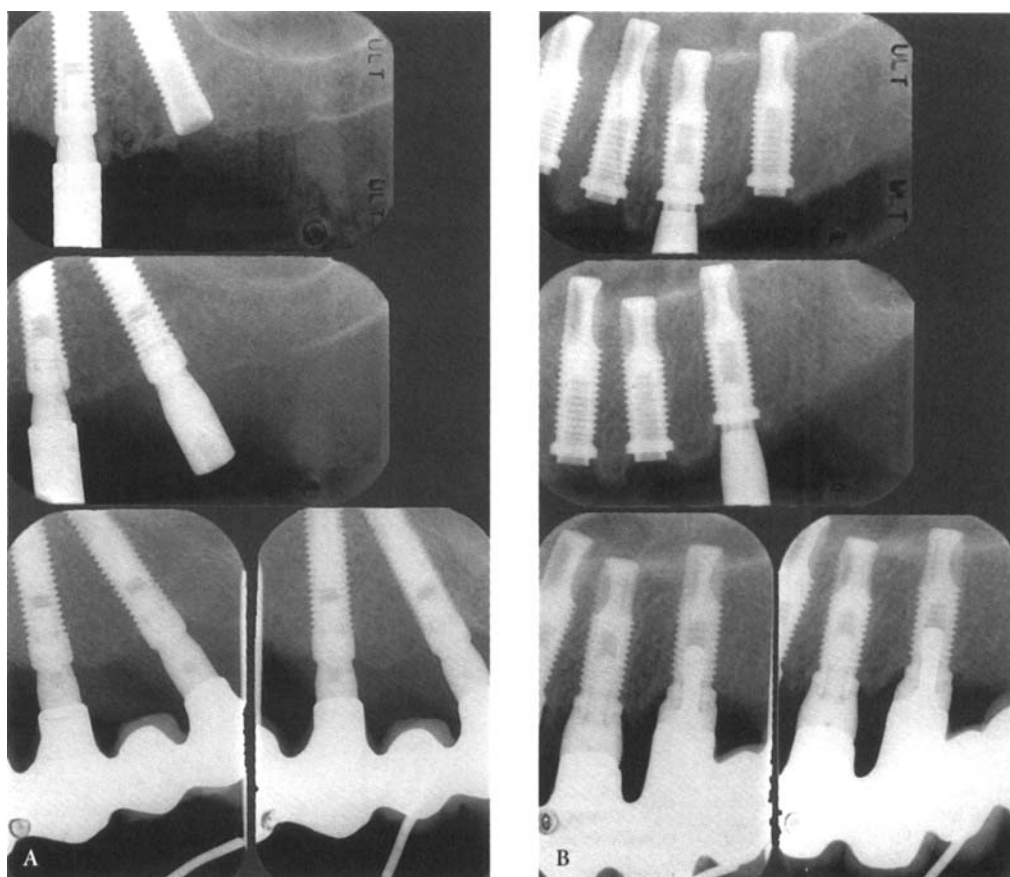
Radiographs of Astra Tech implants (A) and Brånemark System implants (B) from examinations made at fixture installation (*top*), abutment connection (*middle*), baseline (*bottom left*), and 1-year examination (*bottom right*).
